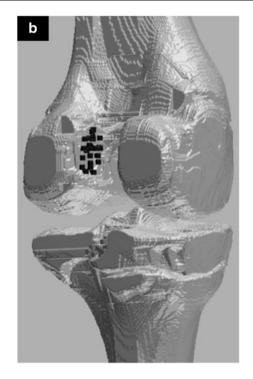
(a) ACL attachments to femur and tibia identified by one user on sagittal proton density MRI in a patient with complete ACL tear. Note that remnant tissue fibers at the bony attachments are clearly visualized. (b) 3D reconstruction showing bony surfaces and the 3D location of the femoral ACL attachment. This can be rotated freely into any orientation. Note that in this view the posterior cruciate ligament (PCL) tibial attachment is also visible.
